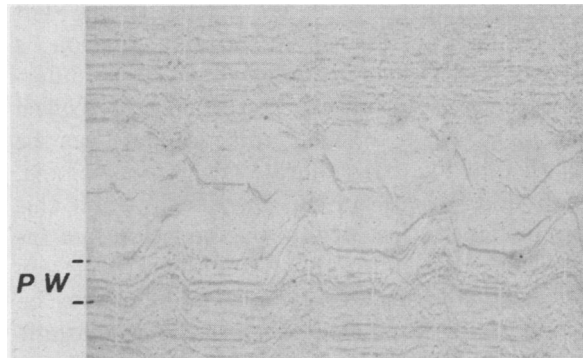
Echocardiogram in a 23-year-old female athlete showing concentric hypertrophy with posterior wall (PW) thickness of 14 mm in diastole. Septal measurements were determined from other portions of the echocardiogram.
